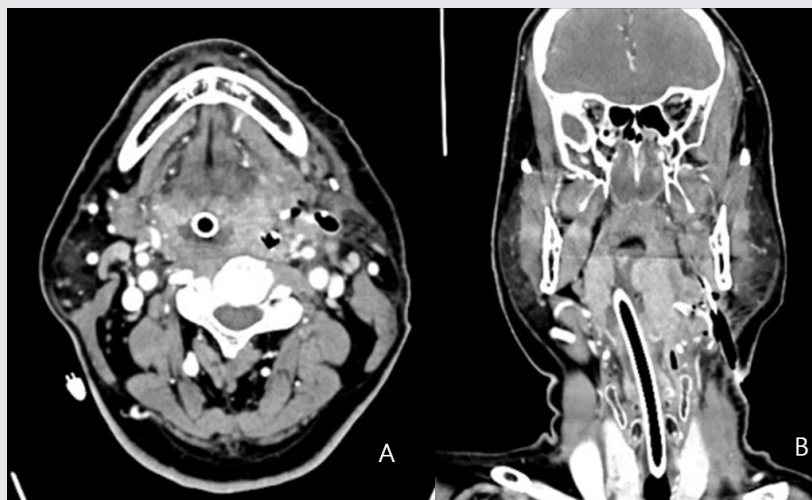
A. Axial view of CT, B. Coronal view of CT. CT shows that the drainage tubes are well inserted into the parapharyngeal space and peritonsillar space. The amount of peritonsillar abscess has decreased. Persistent tonsillitis is apparent on both sides. The airway of the oropharynx has almost disappeared due to edema.
